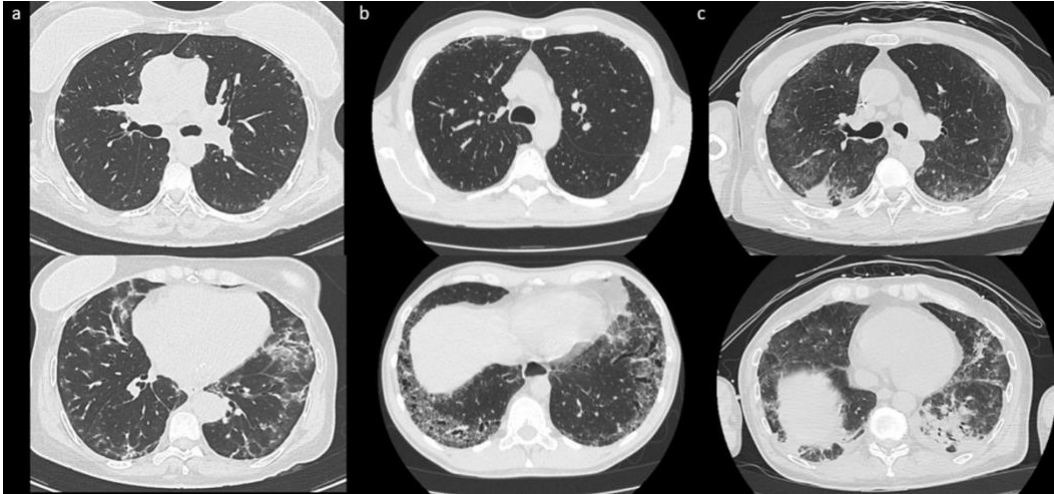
Examples of chest CT patterns in IIM-ILD patients. Axial Chest CT images of: a 60 years old woman with antisynthetase syndrome (aSS) and ground glass opacities (Panel a); a 77 years old woman with aSS and fibrotic changes (Panel b); a 69 years old man with aSS and a consolidative pattern (Panel c).
